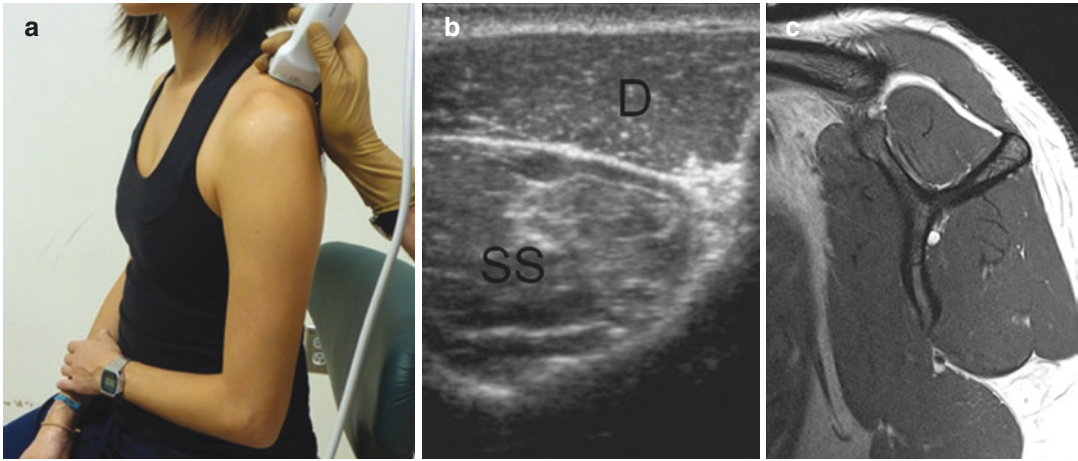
Muscle imaging—supraspinatus patient positioning (a); short-axis sonographic image (b); MRI correlate (c); supraspinatus (SS); deltoid (D)
